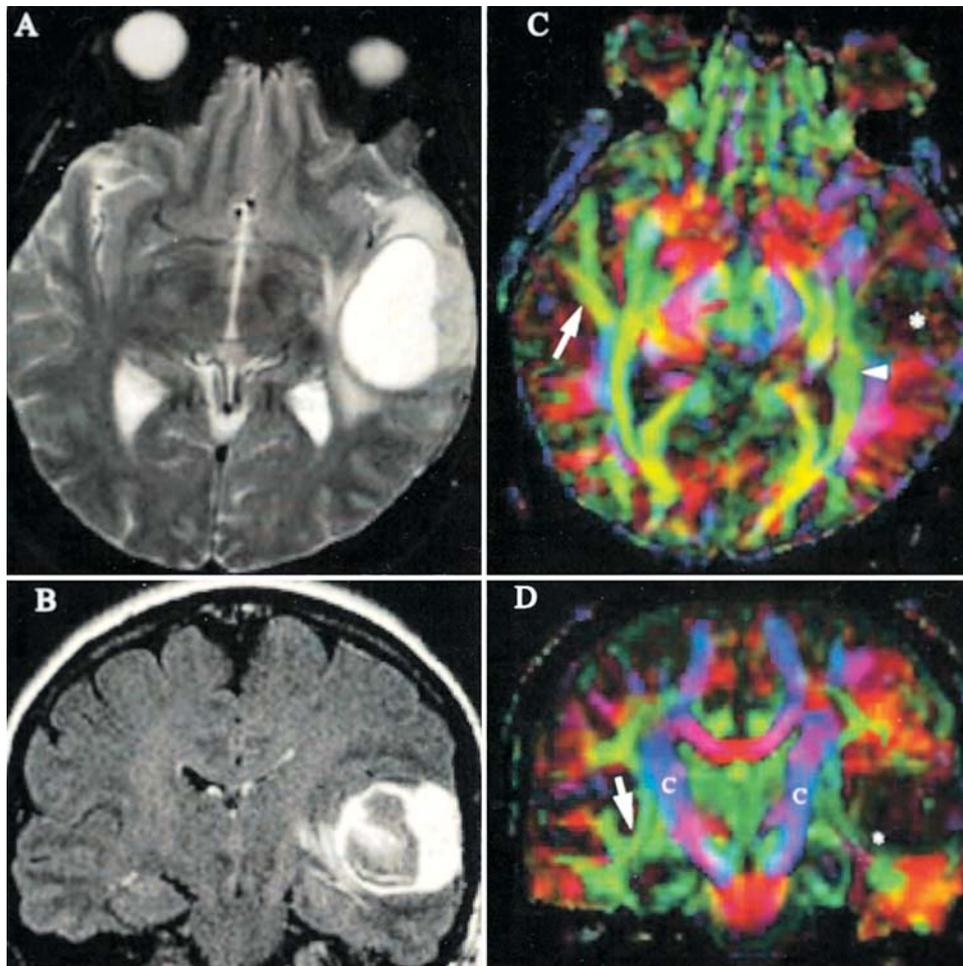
Case 7. Destruction of white matter tracts in a patient with a Grade 4 astrocytoma. A: An axial T_2 -weighted MR image demonstrating a lesion in the left temporal lobe, with an area of surrounding increased signal intensity extending back into the left peritumoral white matter. B: A coronal contrast-enhanced FLAIR image exhibiting a large tumor within the left temporal lobe. C: An axial DT image demonstrating the intact green fibers of the inferior lateral funiculus (*arrow*) within the unaffected temporal lobe of the right hemisphere. Corresponding fibers in the contralateral temporal lobe (*asterisk*) are completely obliterated. Within the region of T_2 signal change in the left peritumoral white matter, the green (anterior/posterior) fibers of the optic radiation (*arrowhead*) appear in their correct anatomical position. D: A coronal DT image demonstrating that the fibers of the corona radiata (*c*) are in their orientation in both hemispheres. The green association fibers of the inferior lateral funiculus are evident within the white matter of the right temporal lobe (*arrow*). The corresponding white matter tracts are no longer present in their normal anatomical location within the left temporal lobe involved by tumor (*asterisk*).
